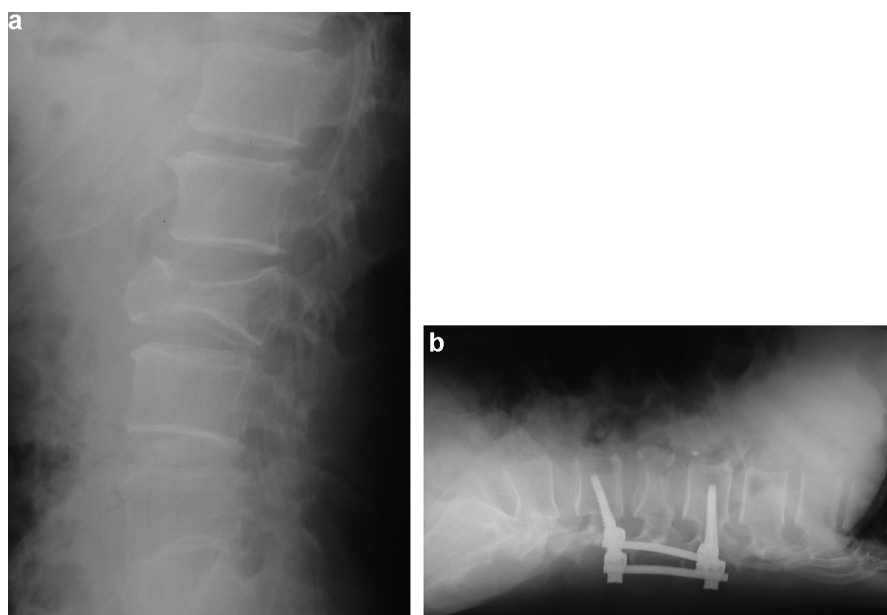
a: pre-operative lateral X-ray showing L3 A3.3 fracture; b: a six-month lateral X-ray showing percutaneous short pedicle fixation with four screws (one level above and below the vertebral fracture) and restoration of the sagittal index.
